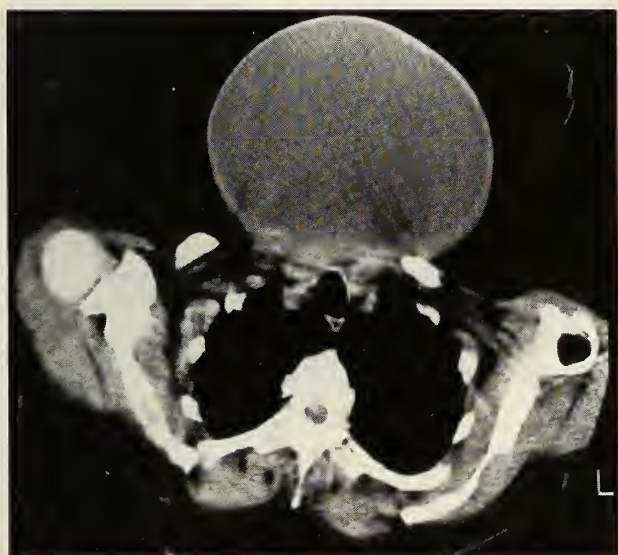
CT scan of neck showing the PA view of a huge cyst.
